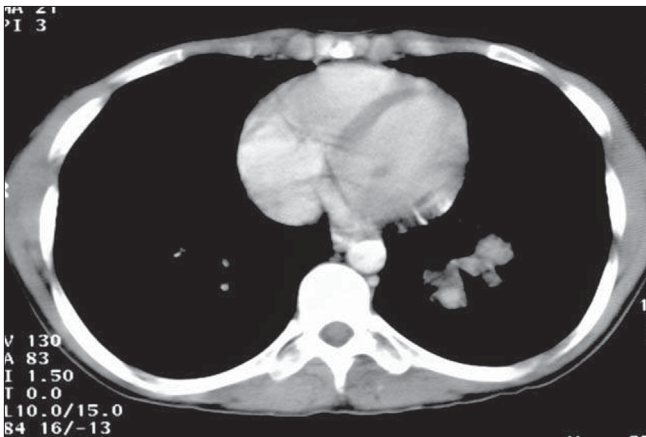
CT chest – mediastinal windows
